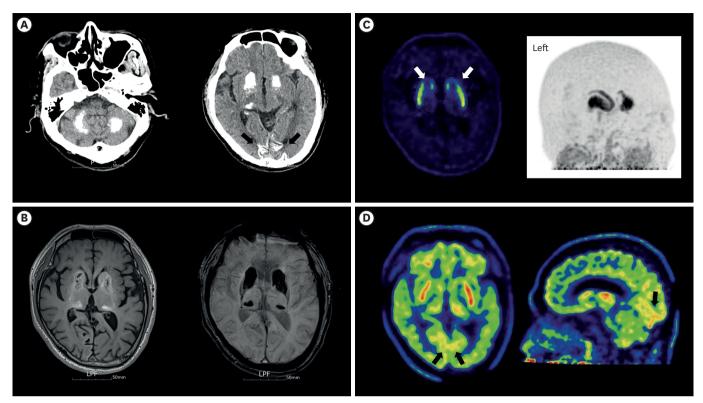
(A) CT image of the patient showing extensive calcification in both basal ganglia, dentate nucleus of the cerebellum, and bilateral occipital cortices (black arrows). (B) High signal intensity lesions were observed in bilateral basal ganglia, thalami, and occipital cortices in T1 weighted images. Low signal intensity lesions were observed in SWIs. However, occipital cortices lesions were not prominent in the SWI scan. (C) Normal dopamine transporter image except for calcified caudate head lesion (white arrows). (D) Early phase study of single photon emission computed tomography of the dopamine transporter showing relatively normal tracer uptake in both basal ganglia, slightly increased uptake in bilateral occipital cortices (black arrows), and diffusely decreased bilateral cerebral cortices.
